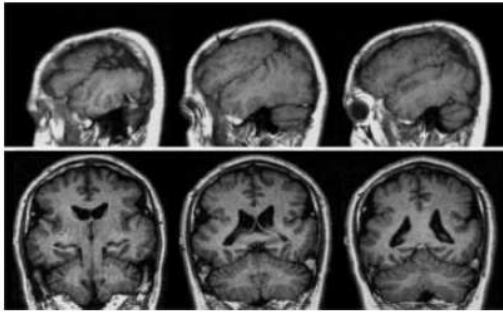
MRI from Patient II-5 (male). T1-weighted sagittal and coronal images showing bilateral perisylvian polymicrogyria extending to both frontal and parietal regions.
